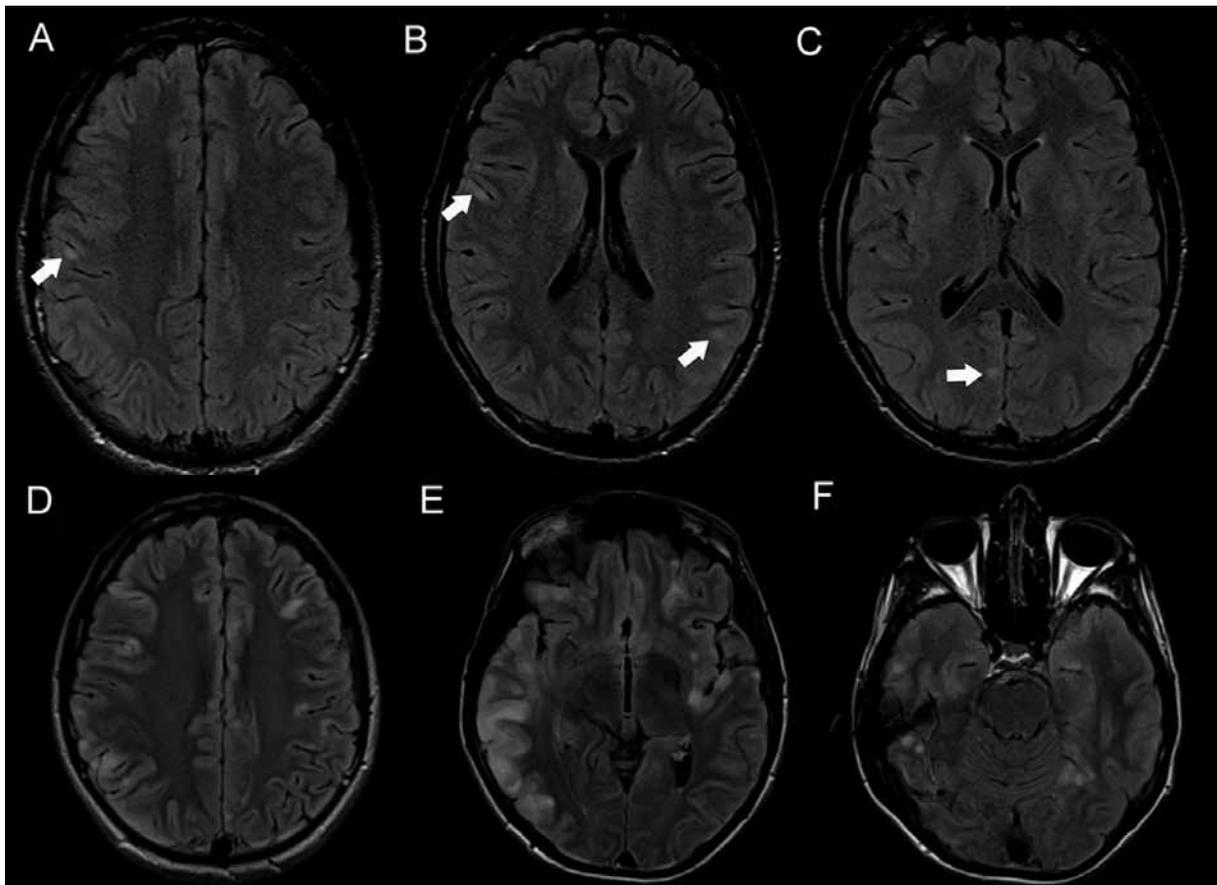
A-C - presence of several subtle foci of increased signal on fluid-attenuated inversion recovery (FLAIR) sequence, associated with restricted diffusion signal on diffusion weighted imaging (DWI) sequence, involving only the cortex on several locations in both cerebral hemispheres. D-F - enlargement of inflammatory process.
